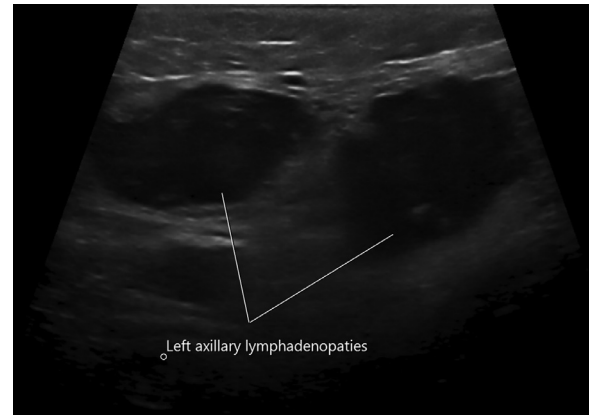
Left Axilla US Scan; Multiple pathologic lymph nodes with irregular margins and complete loss of central fatty hilum and maximum short axis of 16 mm. The cortical outline is not well visualized, suggestive of some degree of tumor replacement (A5). All of the lymph nodes exhibited hypervascularity on color Doppler flow (not shown).
